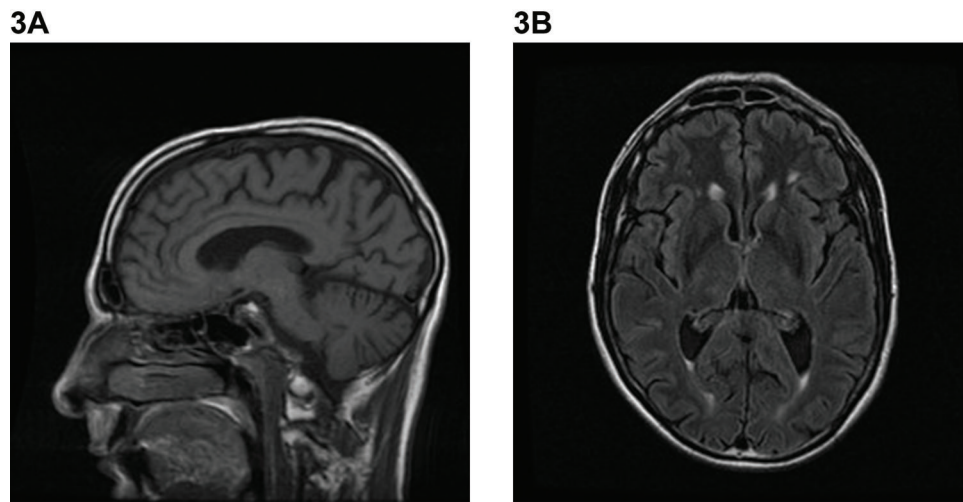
Example of Magnetic Resonance Imaging Findings in Dentatorubral-pallidoluysian Atrophy. (A) Sagittal T1-weighted image demonstrating global cerebral atrophy, with more marked cerebellar atrophy. (B) Axial T1-weighted image demonstrating bilateral periventricular white-matter lesions.
